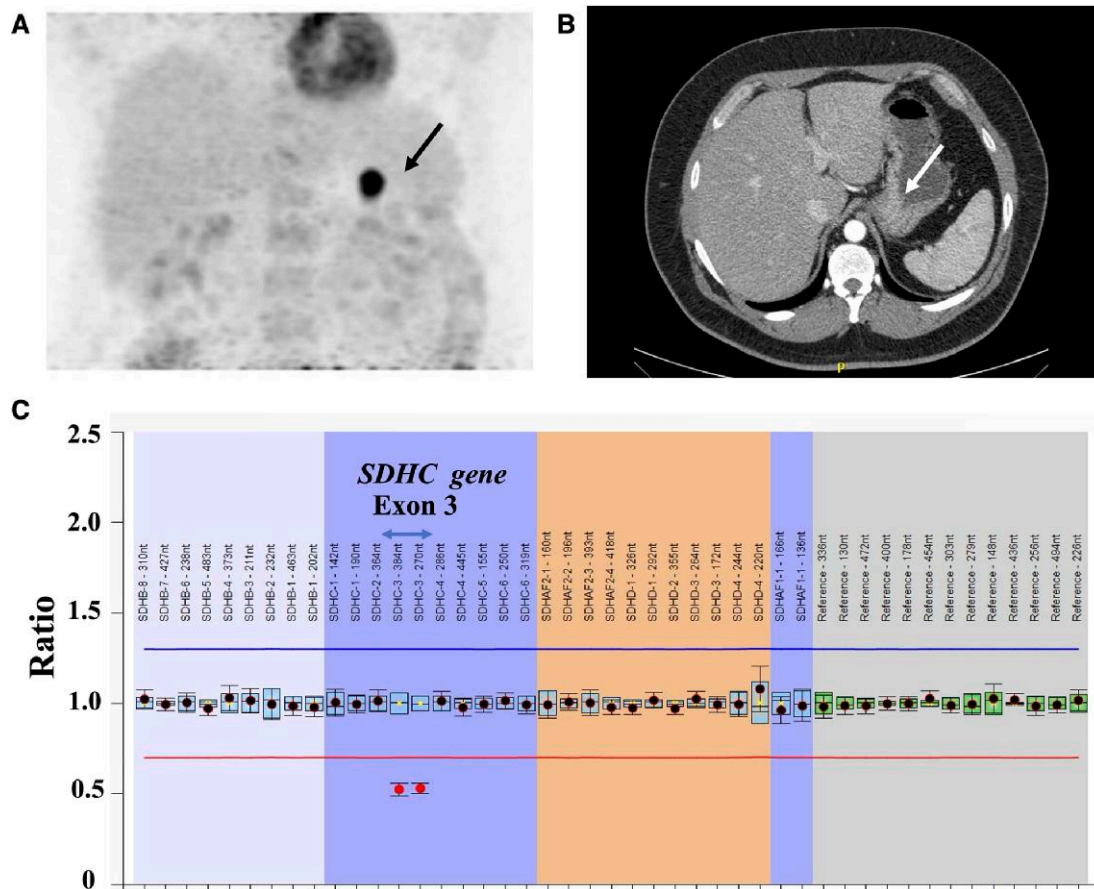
(A) Positron emission tomography (PET)-CT imaging with 2-[(18)F]fluoro-2-deoxy-D-glucose (FDG) revealing an undetermined nodular lesion in the posterior gastric body wall, suggestive of a neoplastic process (black arrow). (B) CT scan revealed a lesion in the gastric body, measuring 1.9 cm (white arrow). (C) Genetic investigation revealed a germline *SDHC* exon 3 deletion detected using multiplex ligation-dependent probe amplification (MLPA). CT, computed tomography; GIST, gastrointestinal stromal tumor.
